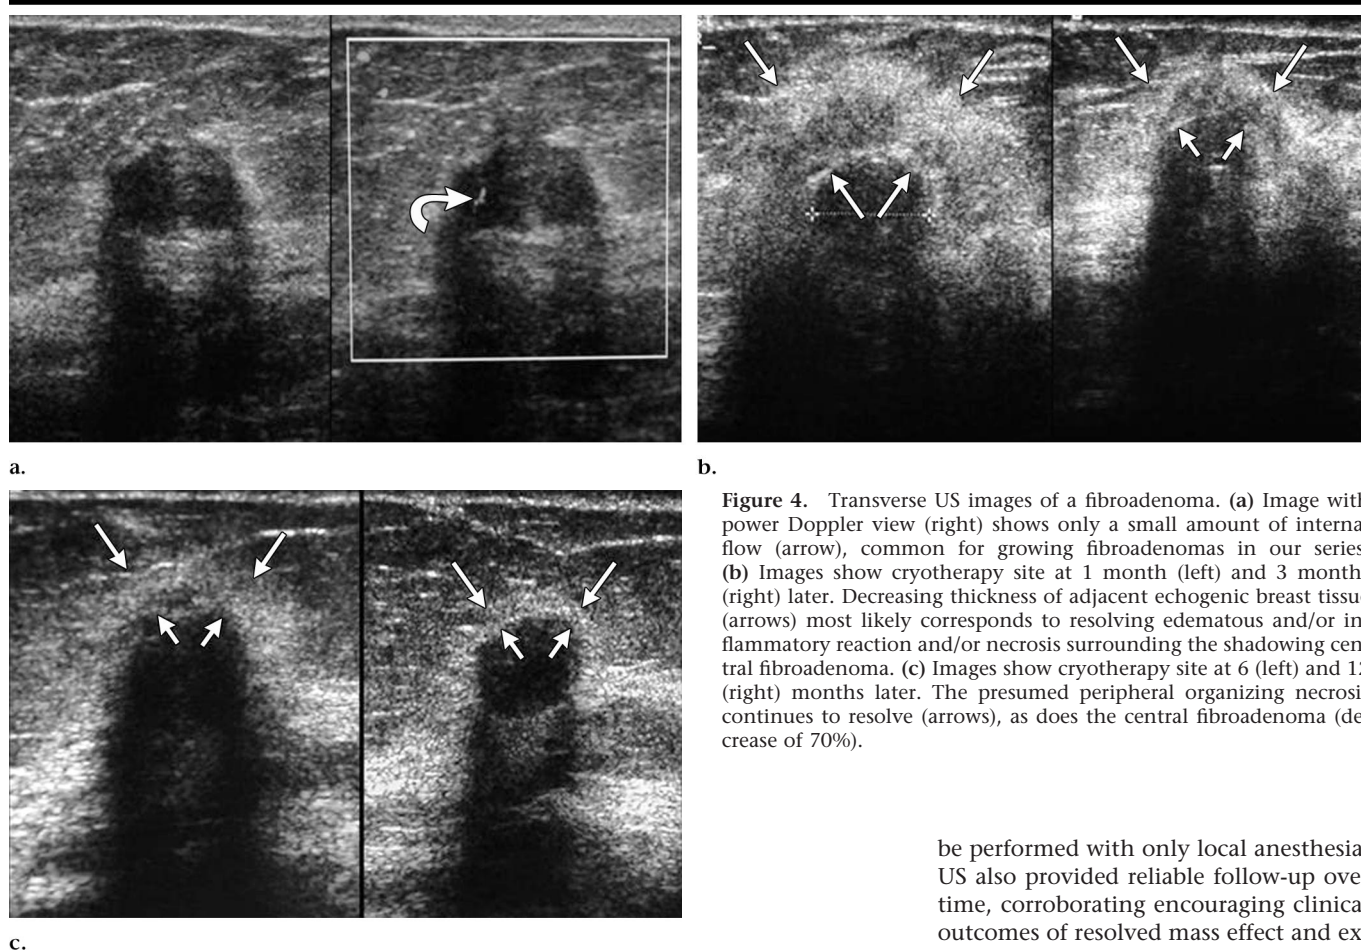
Transverse US images of a fibroadenoma. (a) Image with power Doppler view (right) shows only a small amount of internal flow (arrow), common for growing fibroadenomas in our series. (b) Images show cryotherapy site at 1 month (left) and 3 months (right) later. Decreasing thickness of adjacent echogenic breast tissue (arrows) most likely corresponds to resolving edematous and/or inflammatory reaction and/or necrosis surrounding the shadowing central fibroadenoma. (c) Images show cryotherapy site at 6 (left) and 12 (right) months later. The presumed peripheral organizing necrosis continues to resolve (arrows), as does the central fibroadenoma (decrease of 70%).
